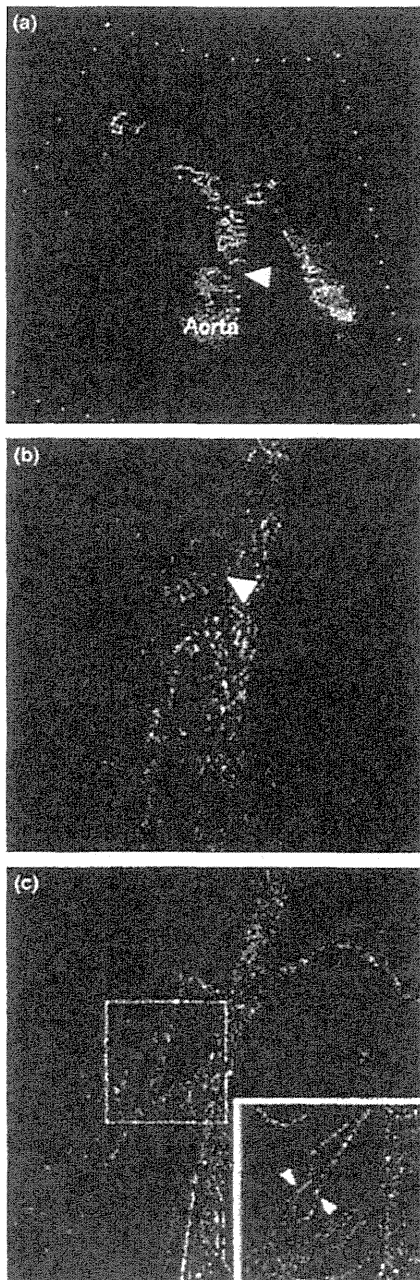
(a) Color ultrasonography showing focal residual stenosis at the proximal celiac artery (arrowhead). (b) CT angiography showing the characteristic hooked narrowing of the proximal celiac artery on a 3D reconstruction image (arrowhead). (c) CT angiography showing the mesenteric hepatic collateral via the pancreaticoduodenal arcade (square box). A partial enlarged view of the lower right shows the collaterals (arrowhead).
